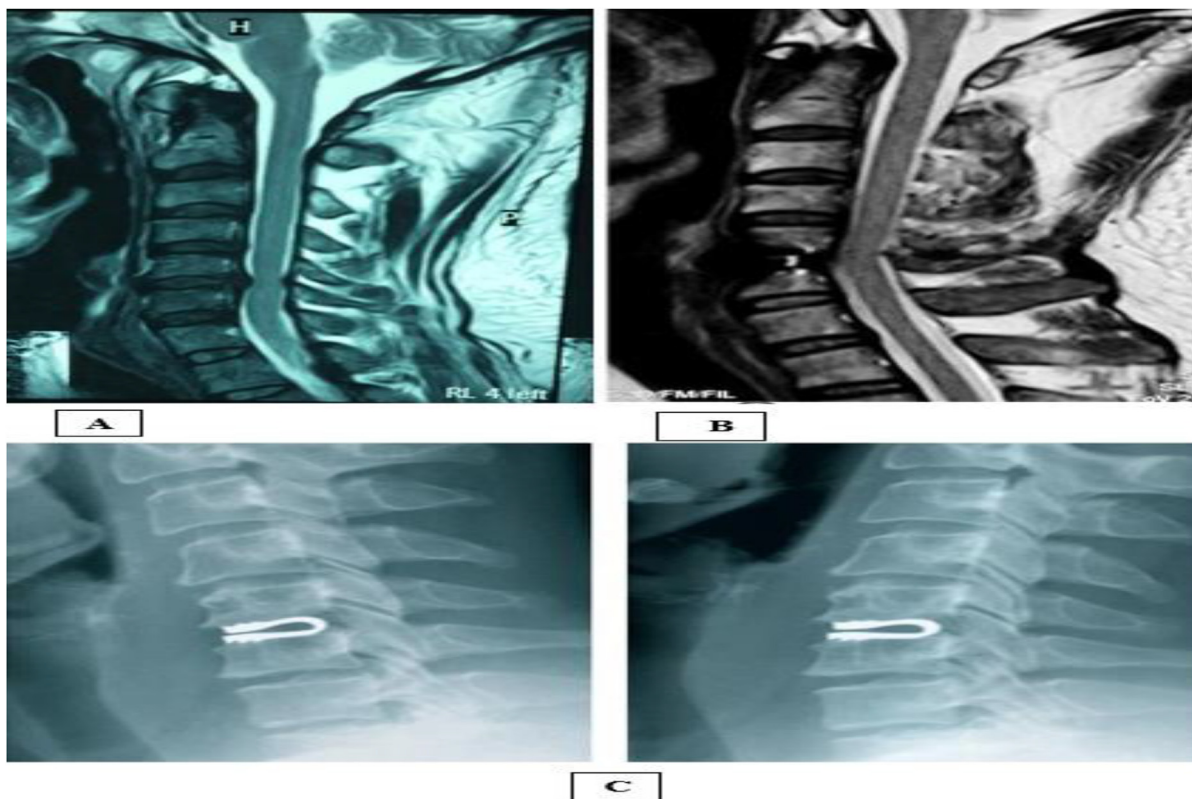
(A) Preoperative MRI cervical spine T2 sagittal view showed C5–6 disc prolapse. Postoperative (B) MRI cervical spine T2 sagittal view showed excision of the herniated disc and decompression of cord; (C) plain radiography of cervical spine dynamic view showed stability of cervical spine, no heterotopic ossifications, and in-place dynamic cervical implant.
